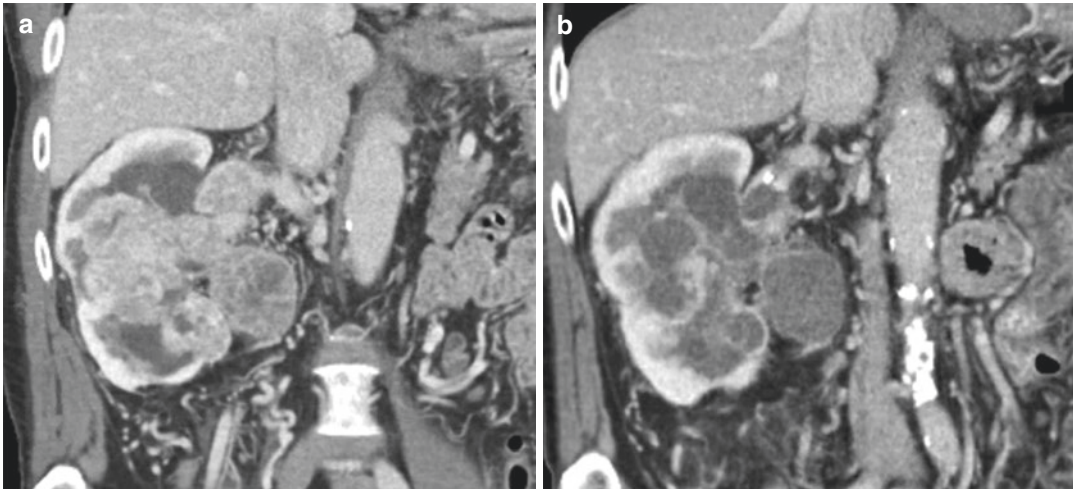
72-year-old man with clear cell renal cell carcinoma, on pazopanib. Baseline coronal contrast-enhanced CT (a) demonstrates a large right renal mass with tumor thrombus extension to the renal vein and enlarged, heterogeneous perinephric adenopathy which have moderately
